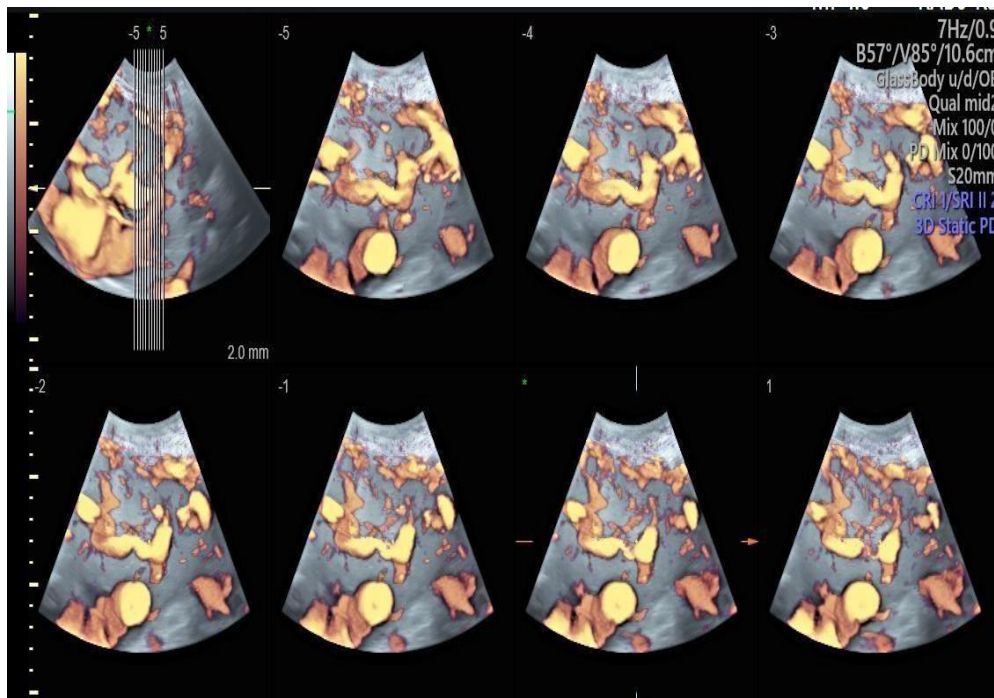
3D multislice color flow Doppler showing hypervascularization of the serosa bladder interface.
